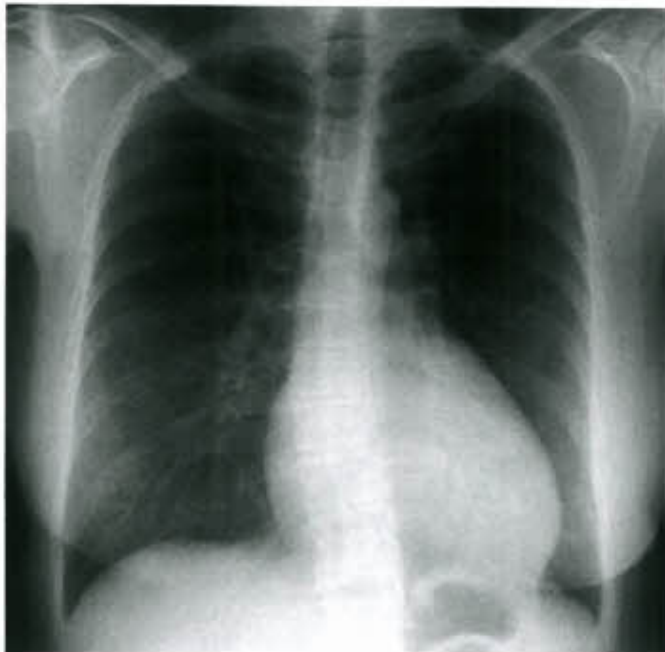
Chest radiograph: of a patient who had Ebstein's anomaly with severe TR and a small ASD before TV surgery. This typical image shows cardiomegaly, a narrow waist, and a cardiothoracic ratio of 0.56. (Used with permission of the Mayo Foundation for Medical Education and Research.)
